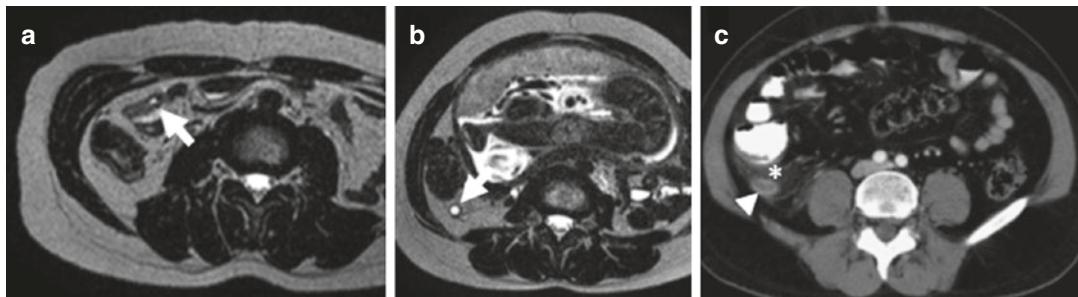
(a) Axial MRI view of the normal appendix (white arrow). The appendix contains no intraluminal fluid. (b) Axial MRI shows a dilated appendix with wall edema and fluid in the lumen (white arrow). (c) Axial contrast-enhanced CT image shows a prominent appendix with periappendiceal rim enhancement due to inflammation (arrowhead). Periappendiceal fat stranding is also visible and marked with asterisk. Adapted from European
